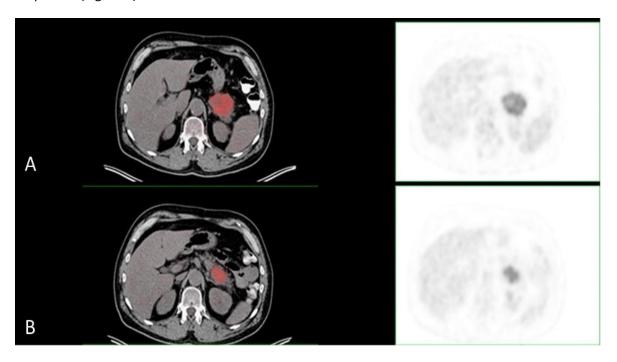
In the PET/CT fusion (B, left) and PET transaxial cross-sectional images (B, right) of a 56-year-old male patient with lung cancer, a lesion measuring 38 mm in size and an SUVmax value of 27.39 was incidentally observed in the pancreatic tail. In the follow-up imaging performed 3 months later (A), the lesion size was measured as 50 mm and the SUVmax value was 29. The pathological evaluation result was found to be compatible with small cell carcinoma metastasis.
